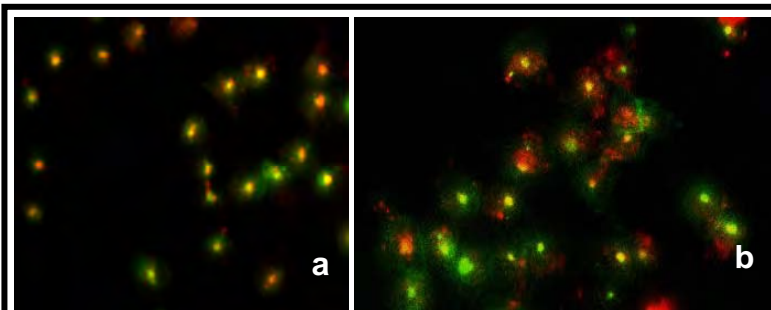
(a) Colocalization of QDs (red) with AlexaFluor 488-transferrin (green) and (b) QDs (red) with FITC-labeled anti-PSMA antibody is seen as yellow in both cases indicating the localization of QDs in recycling endosomal compartments in PC3-PSMA cells.
